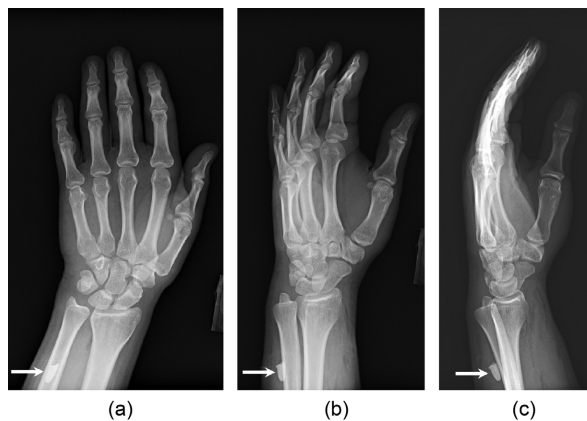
Radiographs of the left hand. (a) Frontal, (b) oblique, and (c) lateral views demonstrate a tooth-like radiodensity in the soft tissues at the ulnar dorsal aspect of the distal forearm (arrows). There is no osseous abnormality.
